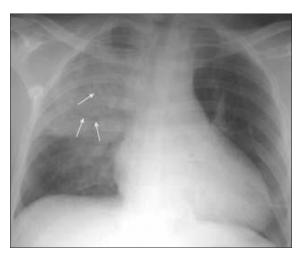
Chest posterior-anterior radiograph showing upper lobe opacity, with air bronchogram (white arrows), in a sputum acid-fast bacilli positive patient
